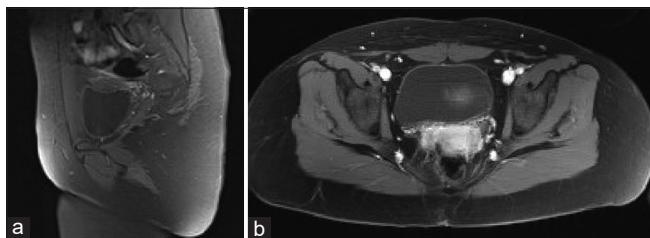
Postoperative magnetic resonance imaging (MRI) imaging. MRI of pelvis taken 6 months postoperative demonstrating no evidence of tumor recurrence or metastatic disease to the pelvis. Sagittal T1-weighted postcontrast image (a) and axial T1-weighted postcontrast image (b) shown above.
